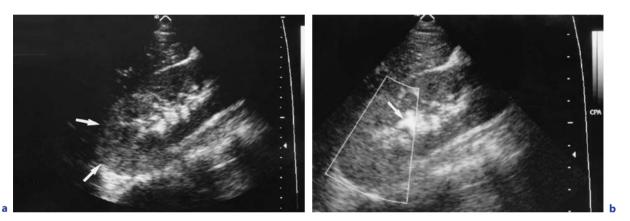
APN and US. a Tumefactive hyperechogenicity of the upper pole of the right kidney (*arrows*). b Power Doppler (*arrow*) reveals lack of vascularization of this area
